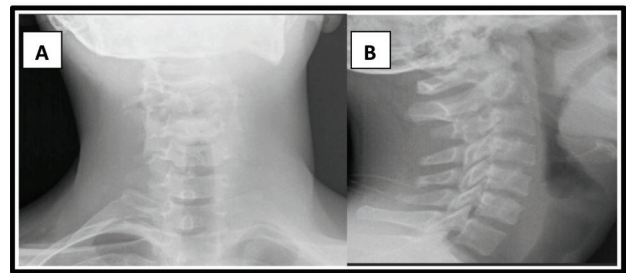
X-Ray Image of Cervical Spine at PA(A) and Lat (B) Positions
